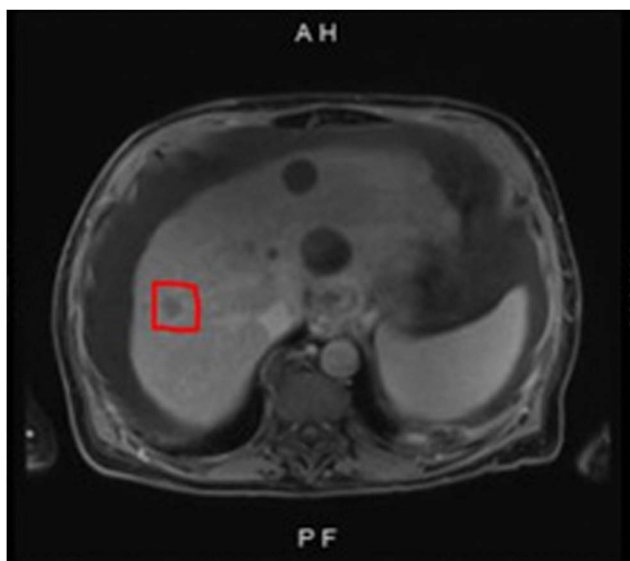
2 LIRADS-3 (LR3) hepatic lesion in segment 8—MRI.
